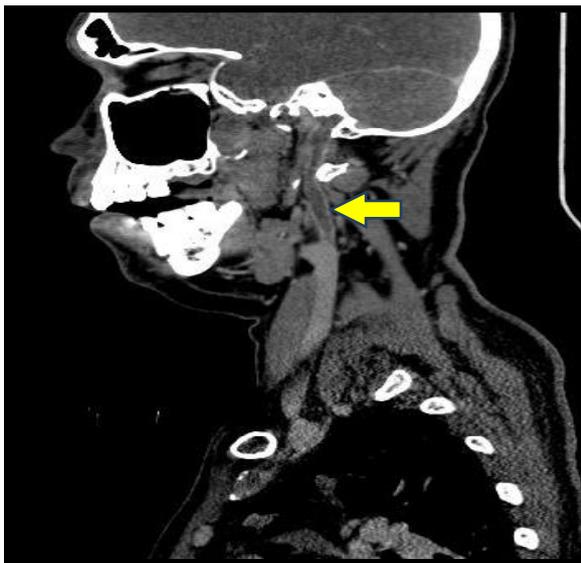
SAGGITAL CT venogram showing intra luminal filling defect suggestive of left IJV thrombosis
